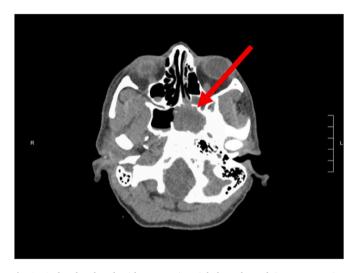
CT head and neck with contrast in axial plane showed tissue attenuation bulging from the left sphenopalatine foramen to the left pterygopalatine fossa.
